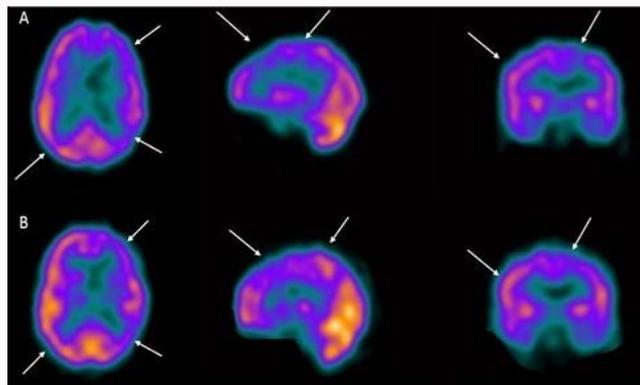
Brain perfusion SPECT (cross-sectional, sagittal and coronal sections) performed after intravenous administration of 1130 MBq of ^{99m}Tc-ECD. Study carried out on a 59-year-old male patient with disorientation in time and space, memory loss of 2 years of evolution and a clinical diagnosis of moderate Alzheimer's disease. Computed Axial Tomography reported moderate generalized cortical atrophy with ventricular asymmetry. A) Study before treatment shows bilateral posterior parietal-temporal hypoperfusion and in the frontal region, somewhat more intense in the left hemisphere. B) Study carried out one year after treatment with NeuroEpo (1 mg intranasal, three times a week) shows an increase in cerebral perfusion in previously affected regions. Arrows point to regions with changes in perfusion. Changes in cerebral perfusion coincided with a clinical improvement.
